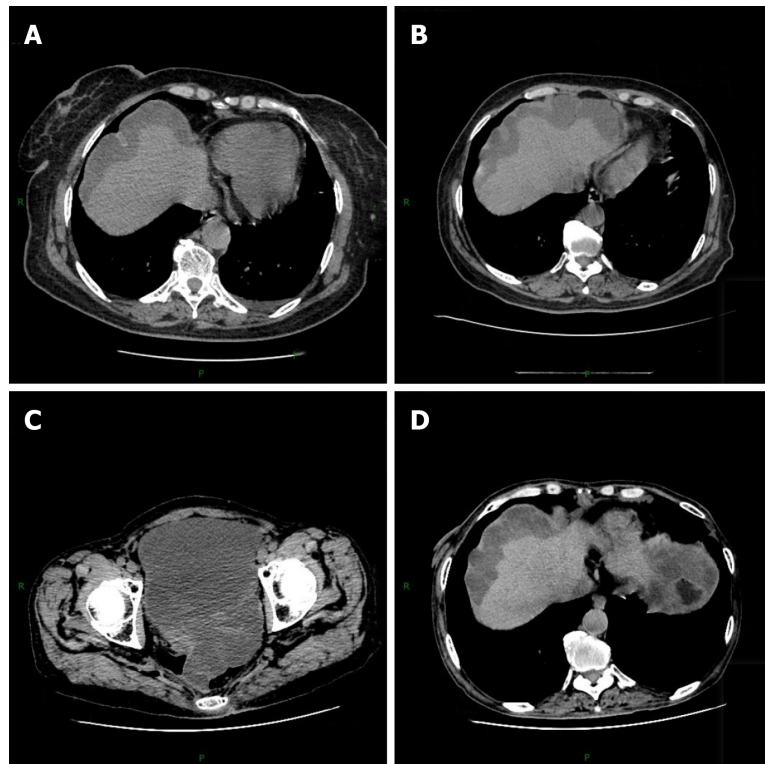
Chest and abdomen computed tomography. A: Before the operative treatment (November 24, 2015); B: After the operative treatment (January 1, 2016); C, D: After the apatinib treatment (December 18, 2017).
